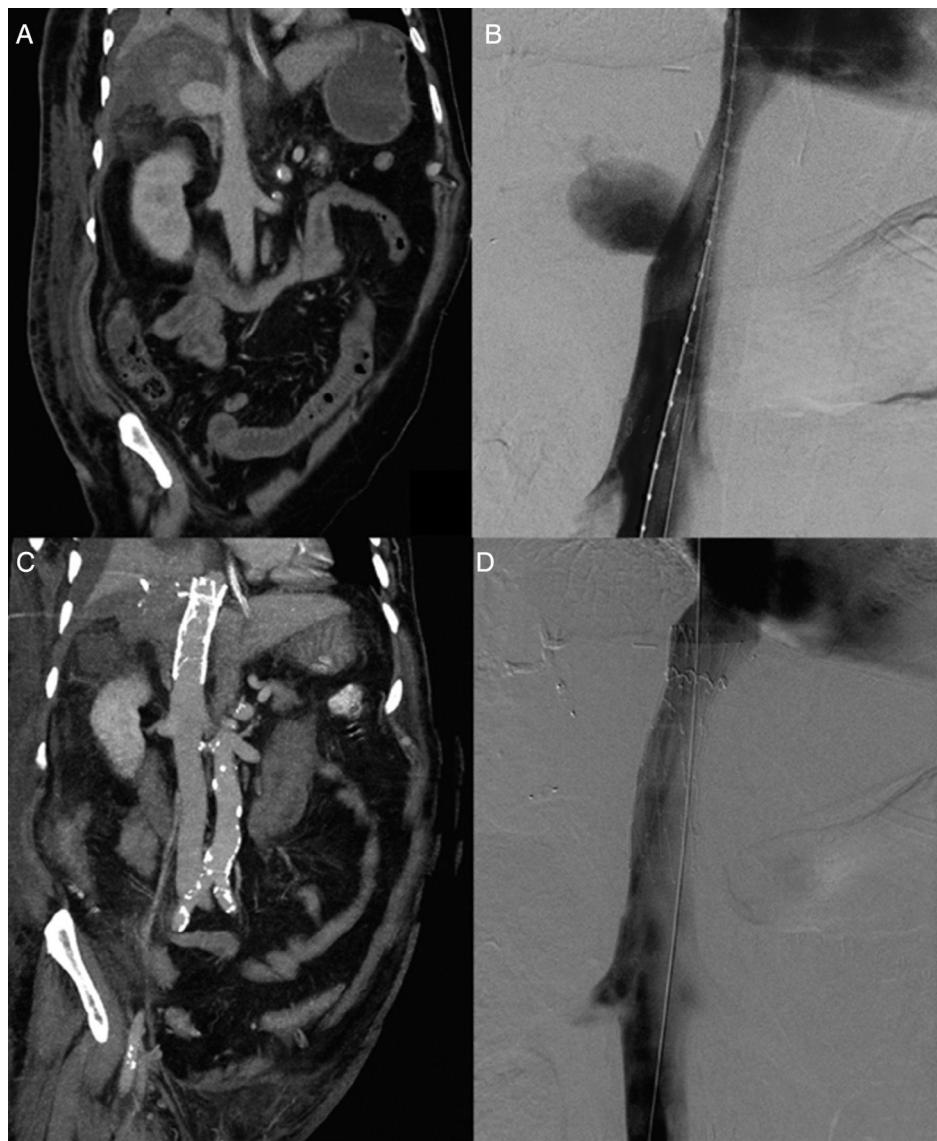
(A) CT angiography, portal phase, coronal plane. Subhepatic IVC pseudoaneurysm is seen and free liquid with high attenuation, suggestive of rupture. (B) Cavogram. Subhepatic IVC pseudoaneurysm is confirmed. (C) CT angiography, portal phase, coronal plane. Stent patency is seen. (D) Cavogram. Stent patency is confirmed.
